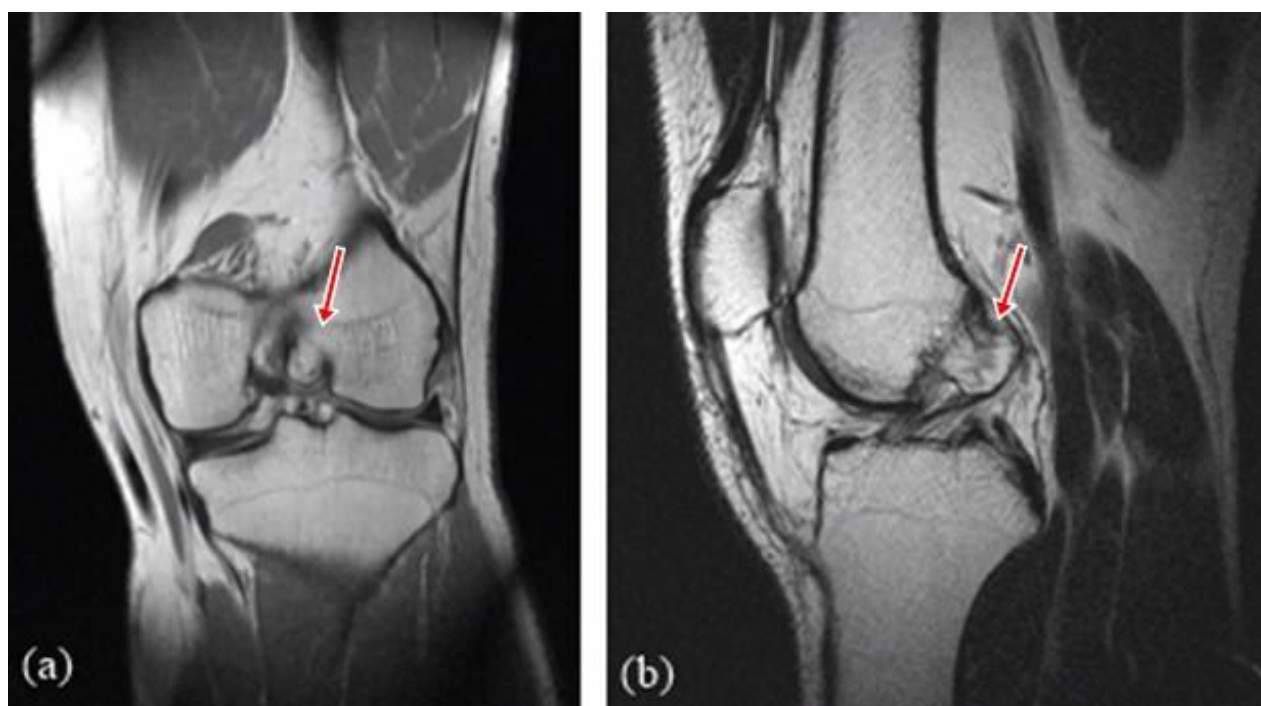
Magnetic resonance images (a, sagittal PD; b, coronal PD) showing an intra-articular lesion with bone signal intensity continuous with the distal femoral epiphysis (red arrow).
